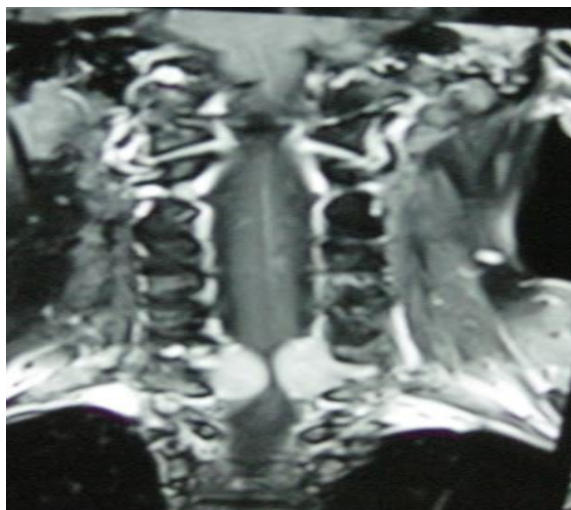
Coronal section of T2 weighted MRI scan of the cervical spine showing collapsed C7 vertebra with soft tissue component compressing the spinal cord.
